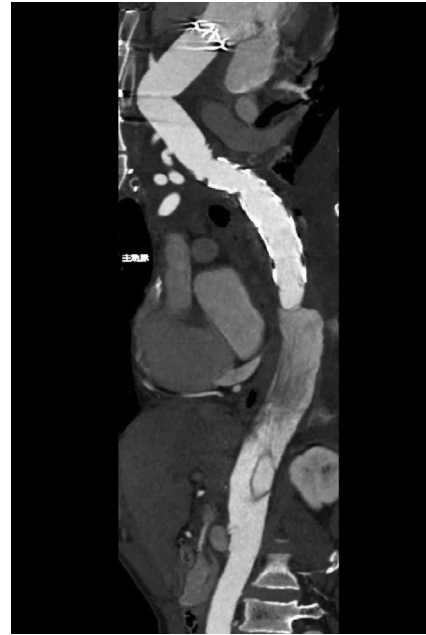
Computed tomography imaging after the first surgery.
